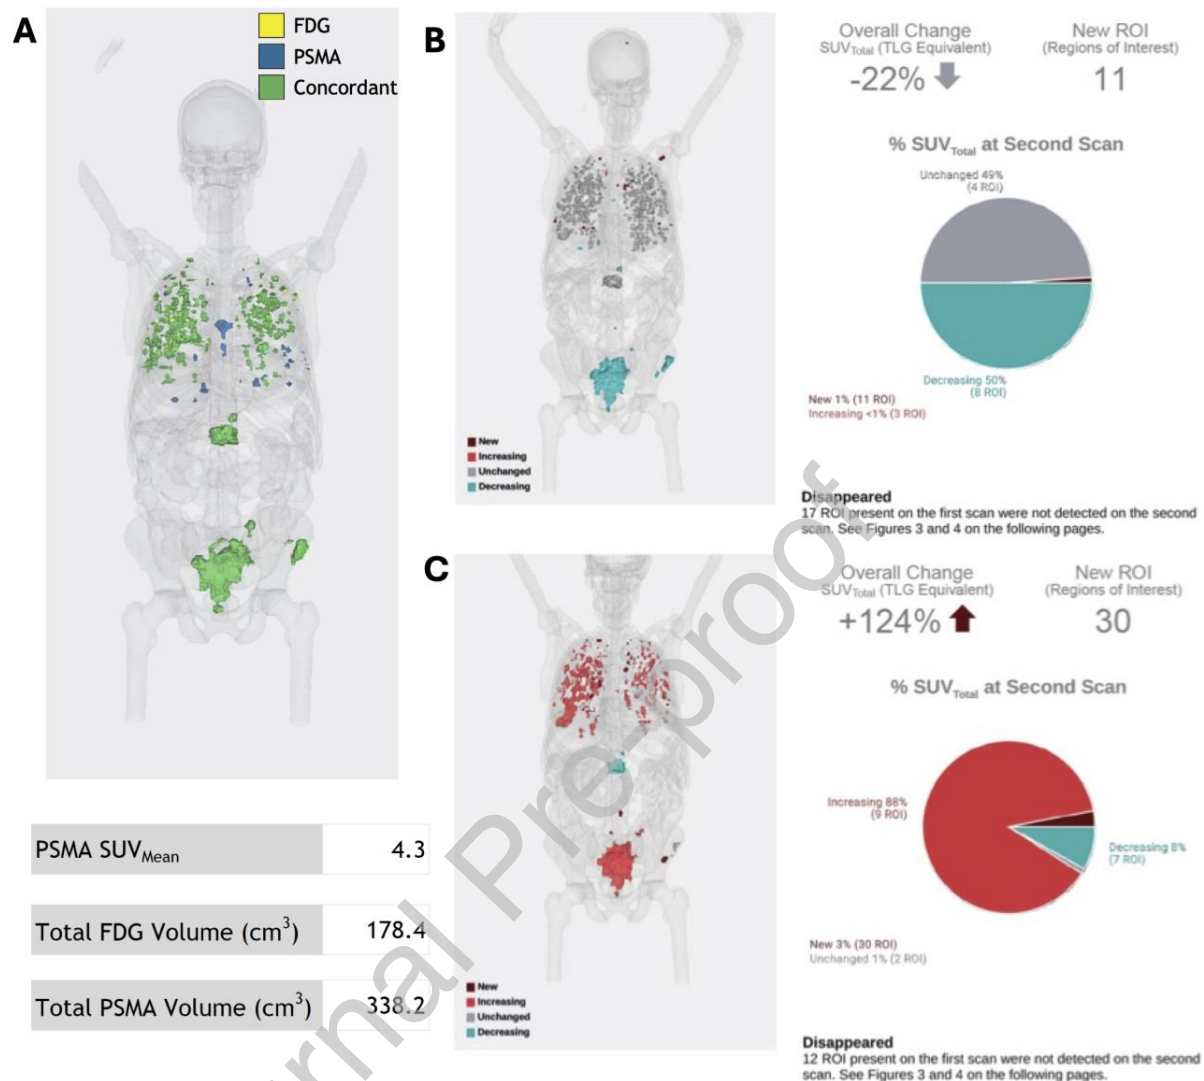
A patient with extensive pulmonary and osseous metastases with a cancer producing little PSA. Pre-therapy PSMA PET showed a low SUV_{mean} of 4 but overall good concordance between PSMA and FDG PET (A). Following 6 cycles of Pluvicto, overall stable disease or response was seen on follow up PSMA PET/CT (stable in gray, response in blue) (B), but comparing a pre to post-therapy FDG PET/CT clearly demonstrated progression of the vast majority of the disease (progression in red) (C).
